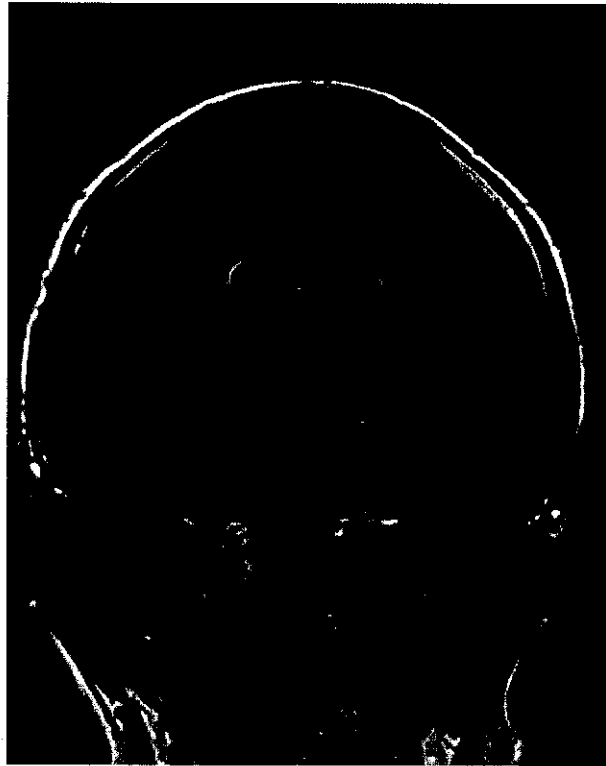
MRI flair sequence demonstrating small vessel disease and hemispheric asymmetry.
